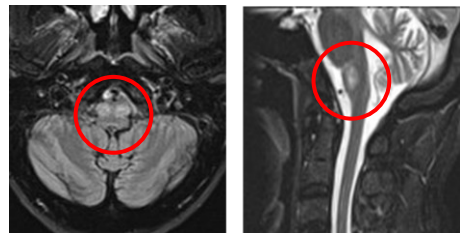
MRI section showing bilateral hyperintensity of the medulla oblongata
